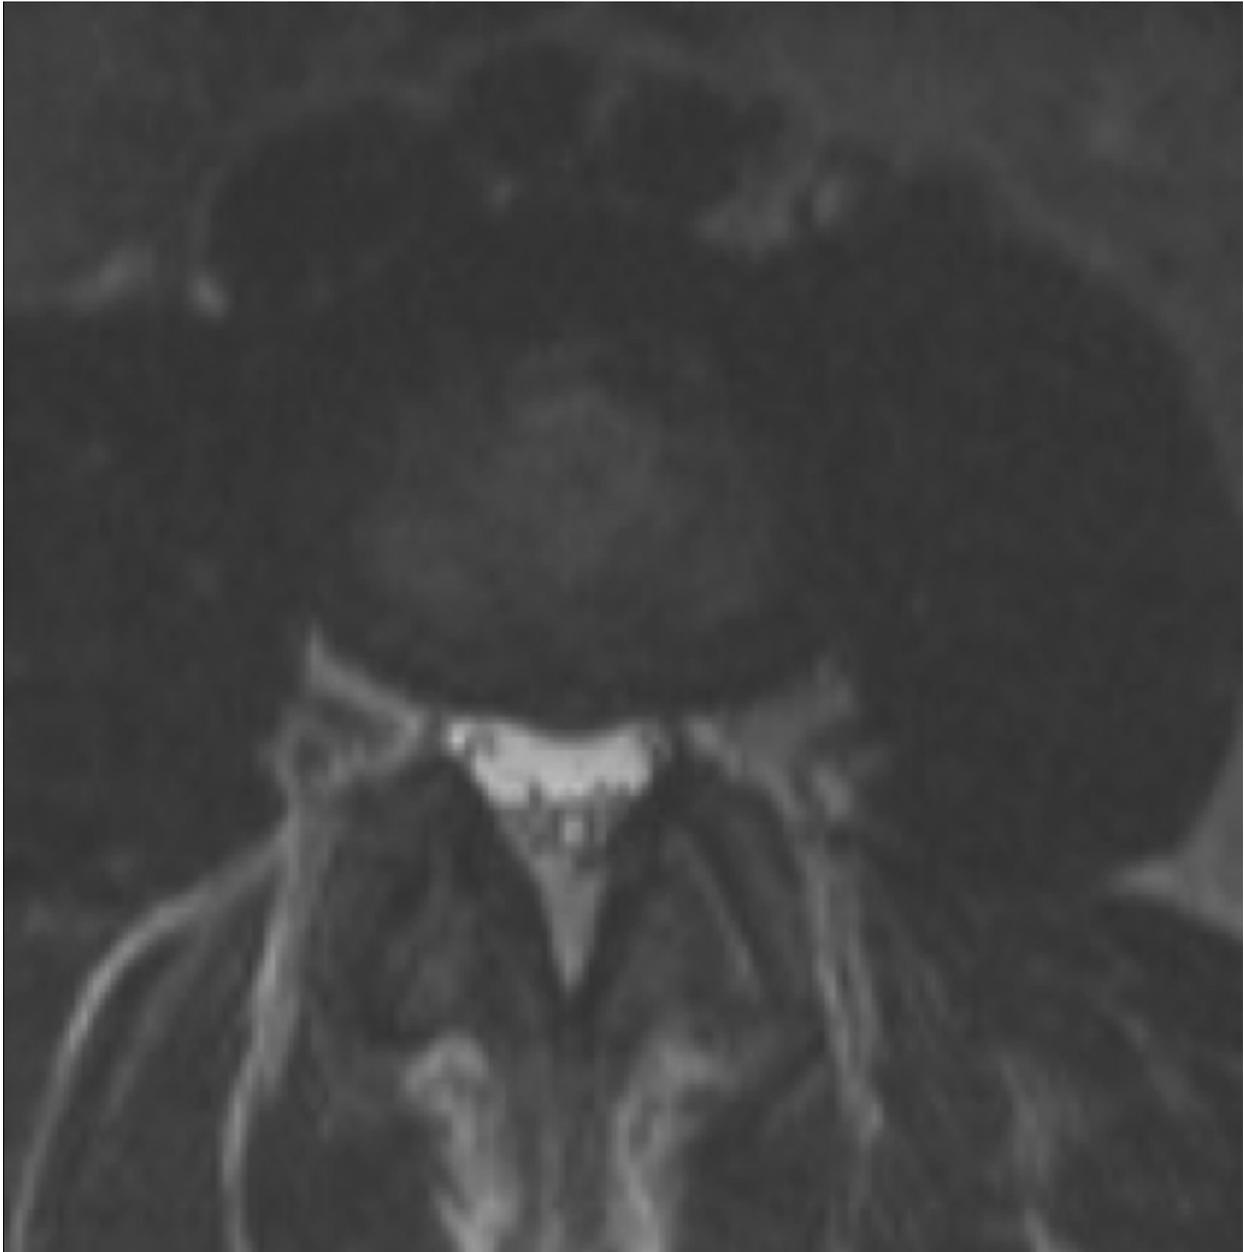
Axial T2 weighted Lumbar Spine MRI image showing small disc protrusion with mild canal compromise.
